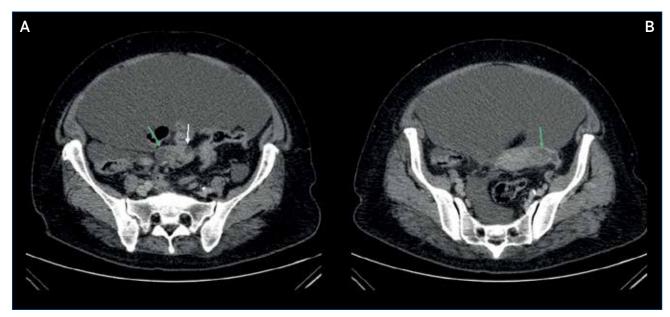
CT of pelvis – postcontrast axial sections. A) Polycystic transformation of right ovary (green arrow) and small leiomyoma of the uterus (white arrow). B) Polycystic transformation of left ovary
